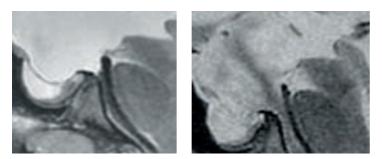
These sagittal T2-weighted MRI scans detail the obliterated prepontine in a patient with aqueductal stenosis. The successful flow across the tuber cinereum following ETV is appreciated by comparing the preoperative image (left) with the postoperative MRI (right).
